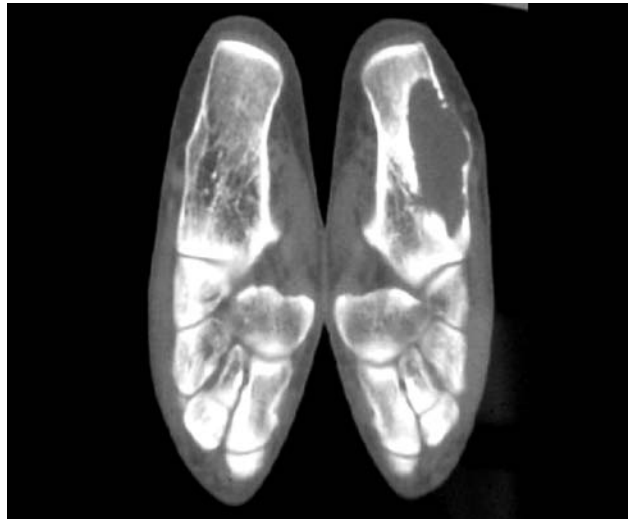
CT scan showing a lytic lesion causing cortical expansion and destruction of the lateral cortex of the calcaneus.
